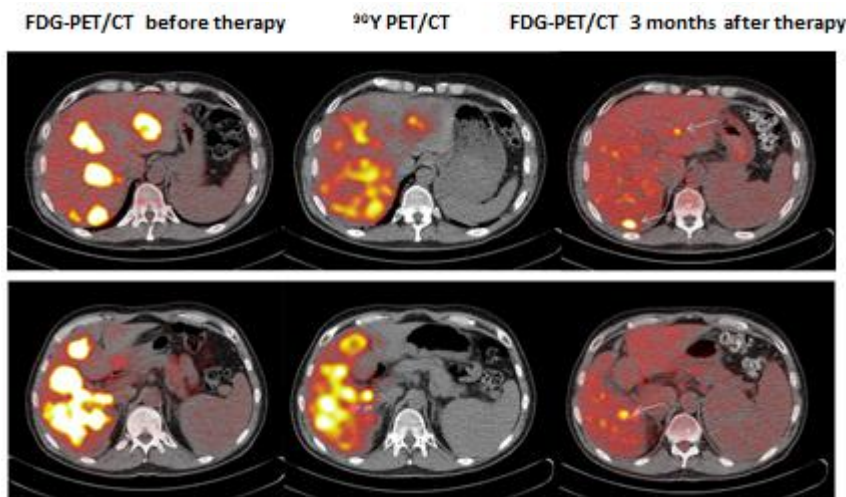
Example of a good local response to radioembolisation. This patient was diagnosed with a metastasized sigmoid carcinoma and was treated with multiple lines of chemotherapy. Sufficient microsphere accumulation in and around the liver lesions is visible after radioembolisation at the ^{90}Y -PET/CT (^{90}Y -dosage 2.0 GBq, total liver volume 1600 ml, estimated tumor volume 620 ml). A very good response is seen at the ^{18}F -FDG PET/CT after three months [6].
